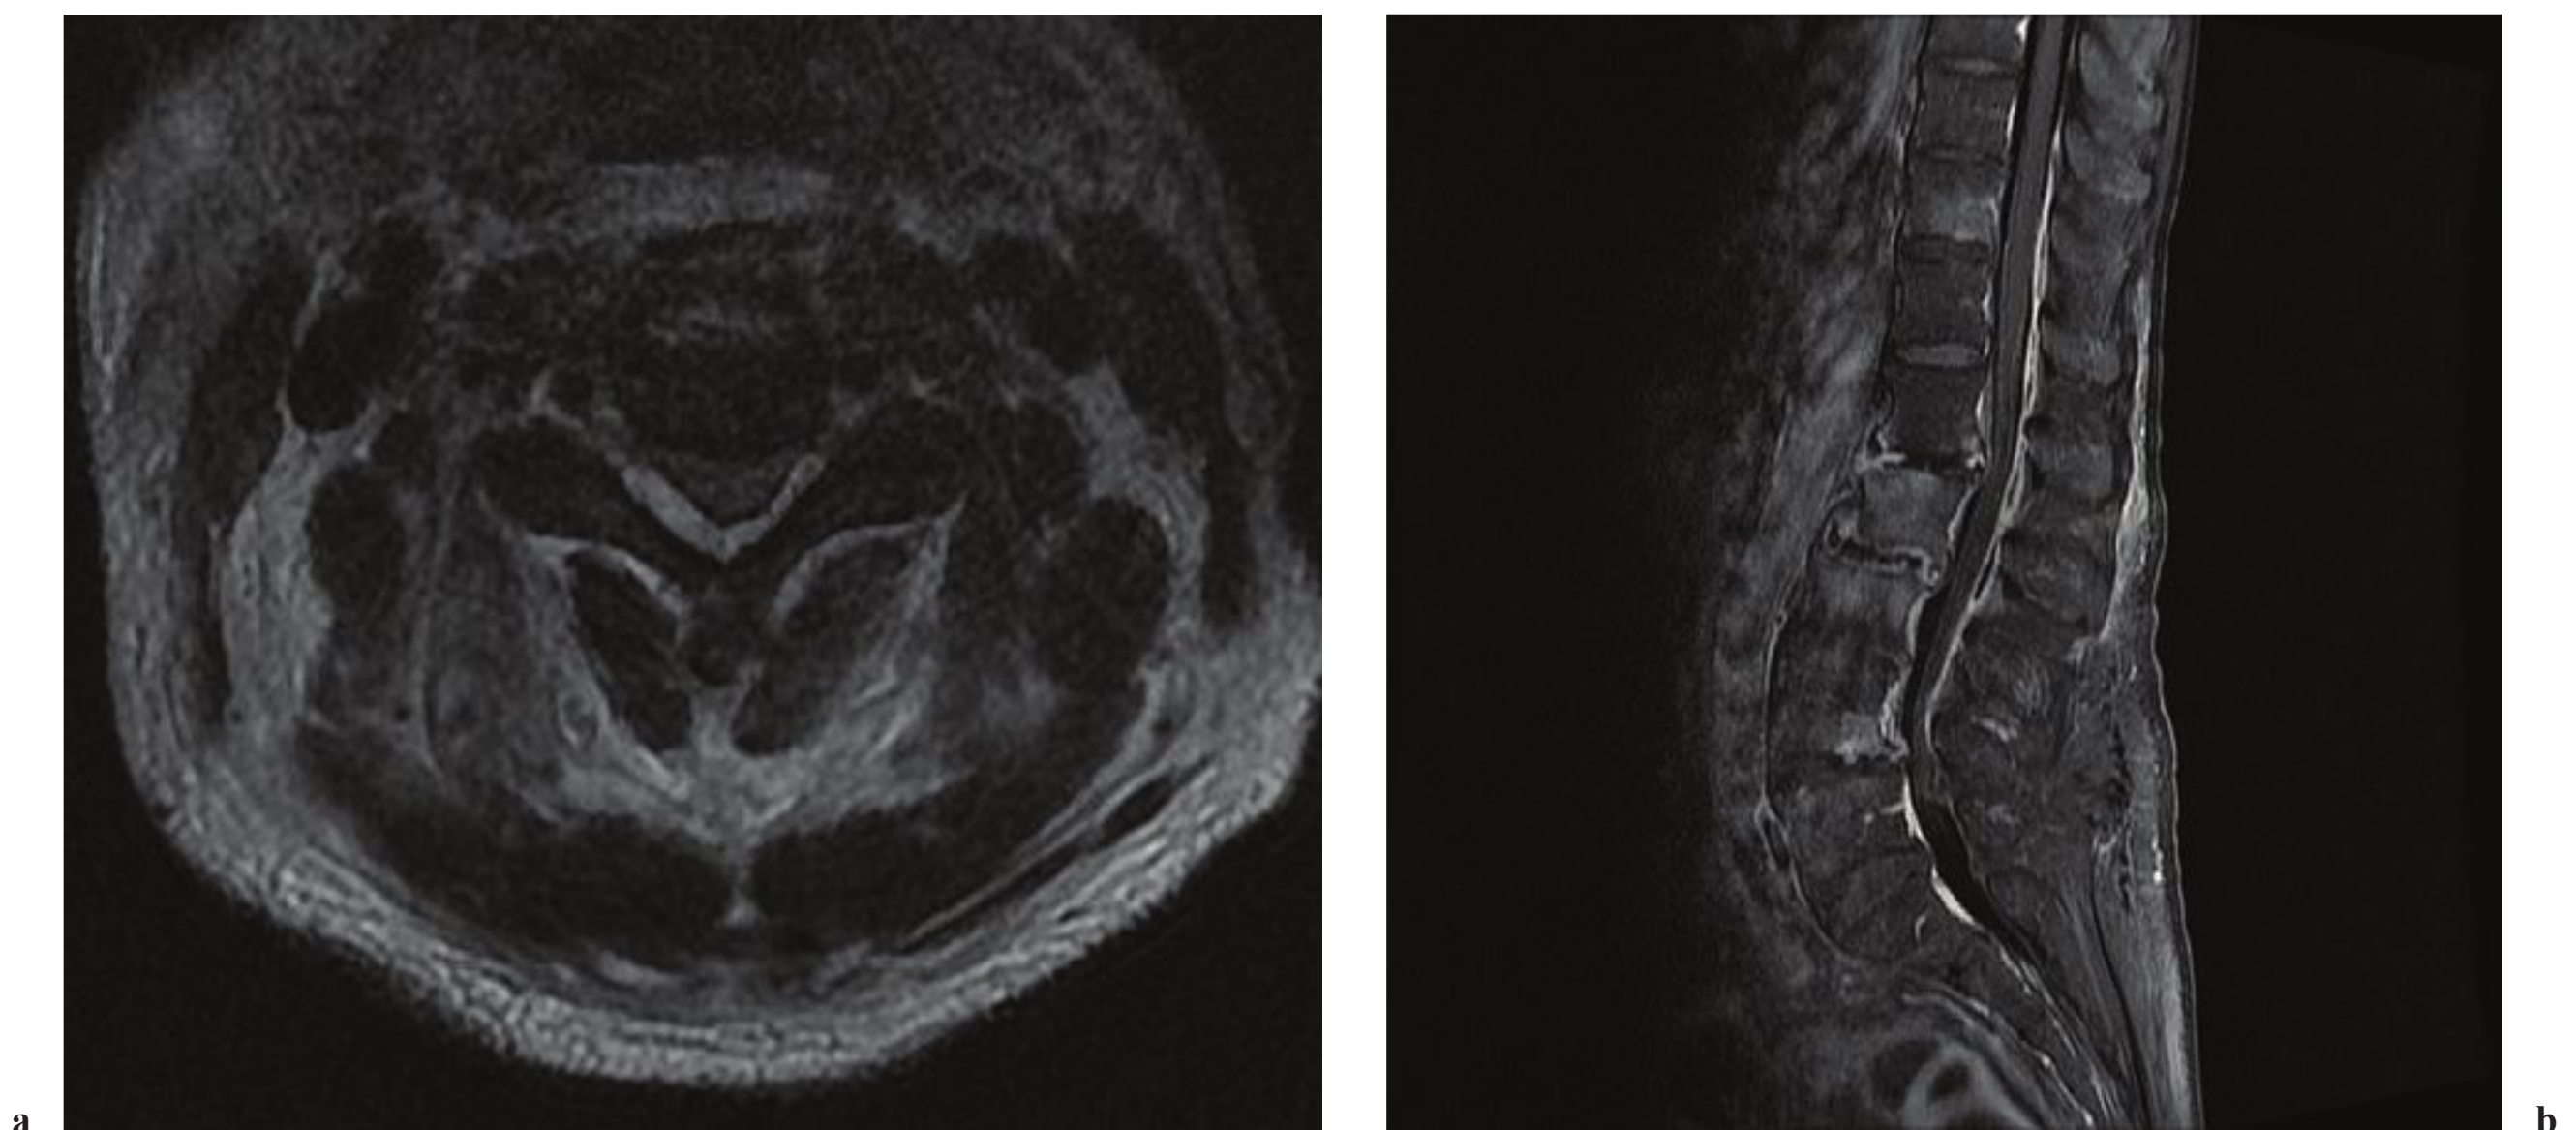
Spinal epidural abscess. (a) Axial T2-weighted MRI of the cervical spine in a patient who presented with acute rapidly progressive paraplegia and respiratory failure. There is a large dorsal epidural abscess collection with cord compression. (b) Sagittal postcontrast image of a posterior thoracolumbar spine abscess associated with multiple areas of vertebral body osteomyelitis including T1, L2 through L5, and diskitis at L23.
